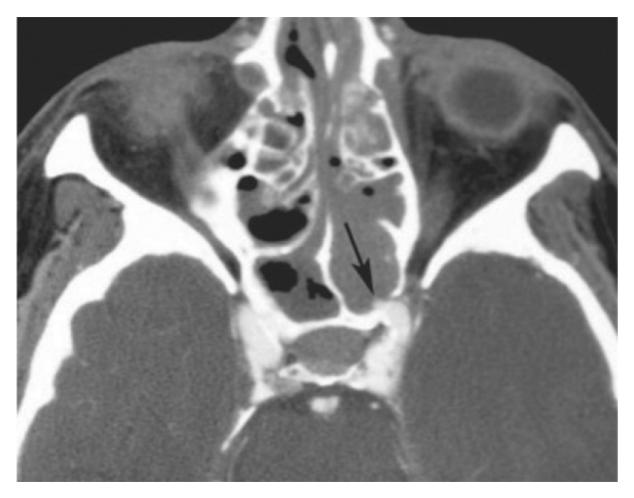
A computed tomographic angiogram of a patient referred after endoscopic sinus surgery complicated by profuse hemorrhage demonstrates a pseudoaneurysm of the internal carotid artery (arrow).
